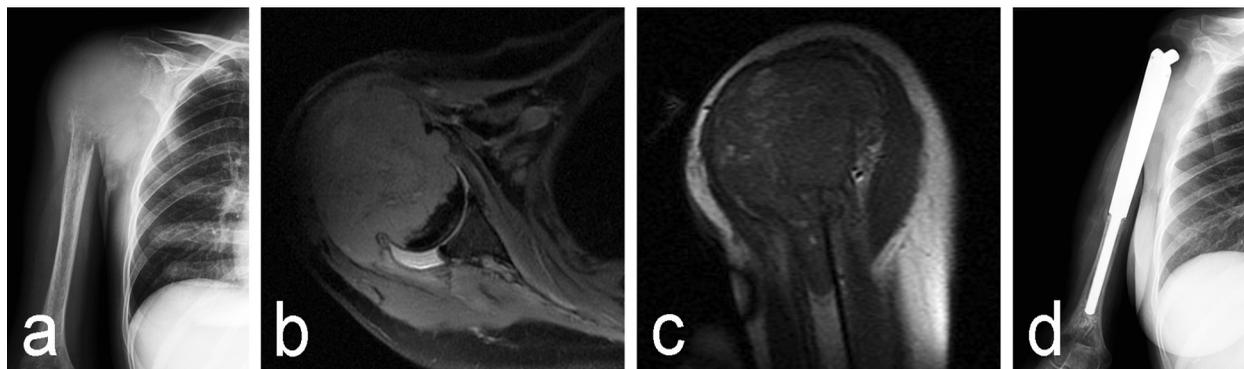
Preoperative AP radiograph (a) and MRI slices (b, c) of a GCTB of proximal humerus; d) AP view after wide resection and replacement of the proximal humerus with a custom-made prosthesis.
